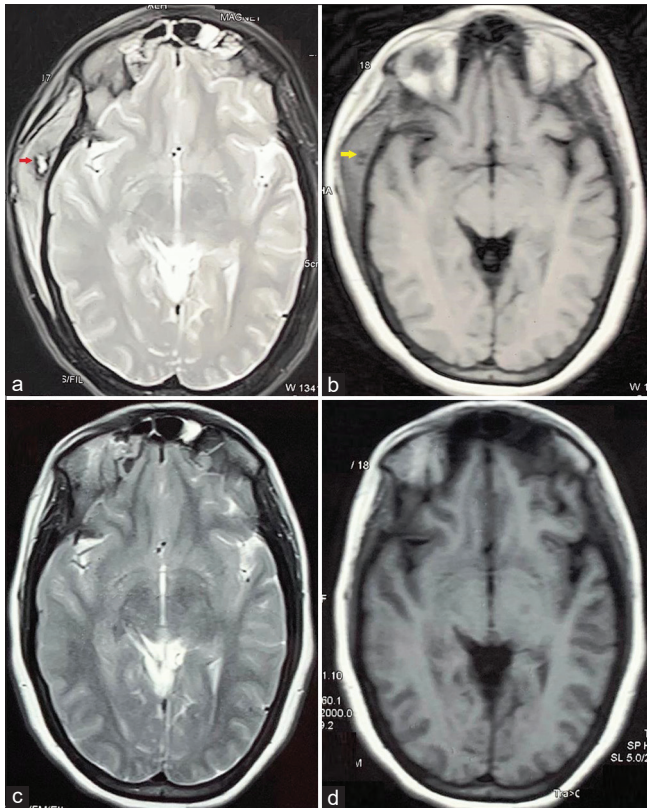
(a) T2-weighted magnetic resonance imaging showing bulky right temporalis muscle with hyperintense lesion and hypointense ring surround it (red arrow). (b) T1-weighted magnetic resonance imaging showing hypointense right intra temporalis muscle lesion (yellow arrow). (c and d) Follow-up magnetic resonance imaging at 6 months showing complete resolution of the lesion
